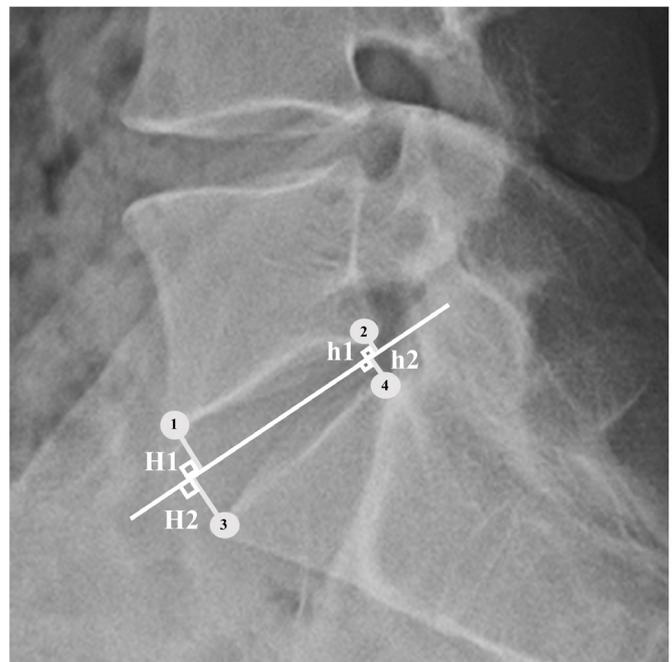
Disc height measurement according to the Frobin method. The four corners of the vertebral segments are designated on the lateral radiographs (1, 2, 3, 4). The medial point, medial plane (median line), and its bisector are shown. Disc height is the sum of the lines perpendicular to the bisector from the corners of the upper and lower segmental vertebrae divided in half. Disc height= $(H1+H2+h1+h2)/2$.
